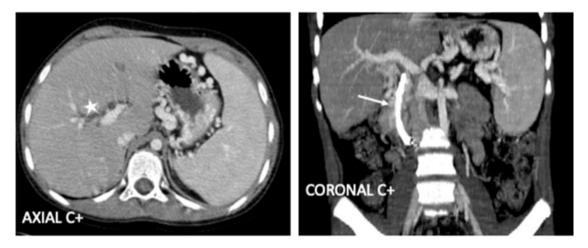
Abdominal CT scan showing a dilation regression of the bile duct (star) after the introduction of the prosthesis (arrow)
